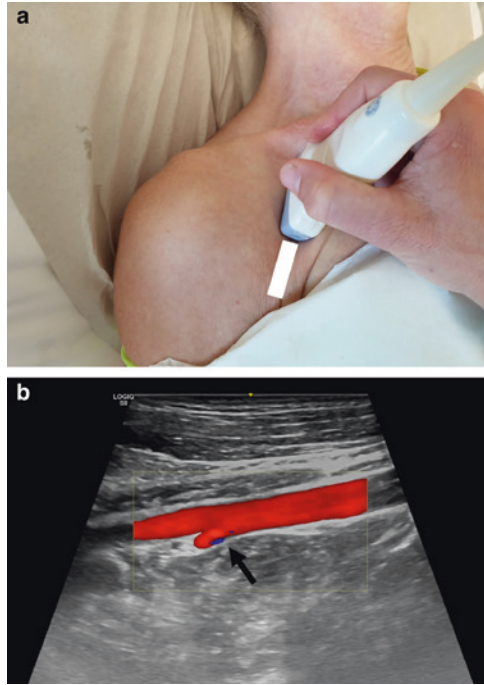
Examination of the proximal axillary artery: a recommended transducer position, b ultrasonographic view (subscapular artery-black arrow)
